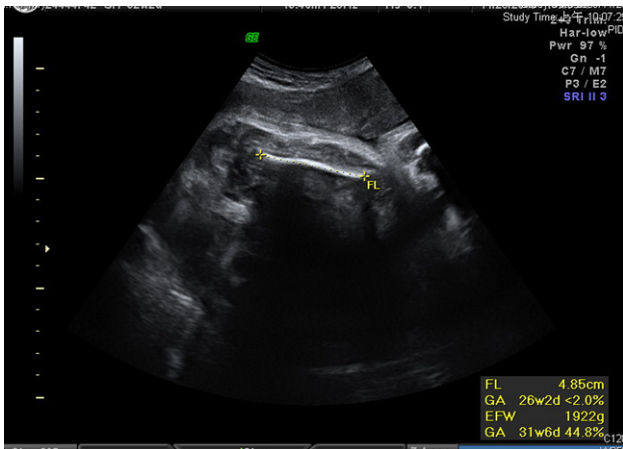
Two-dimensional ultrasound at 32 weeks' gestation revealed rhizomelic shortening of the extremities. Femur length (FL) = 4.85 cm; about 26 weeks' gestation.
